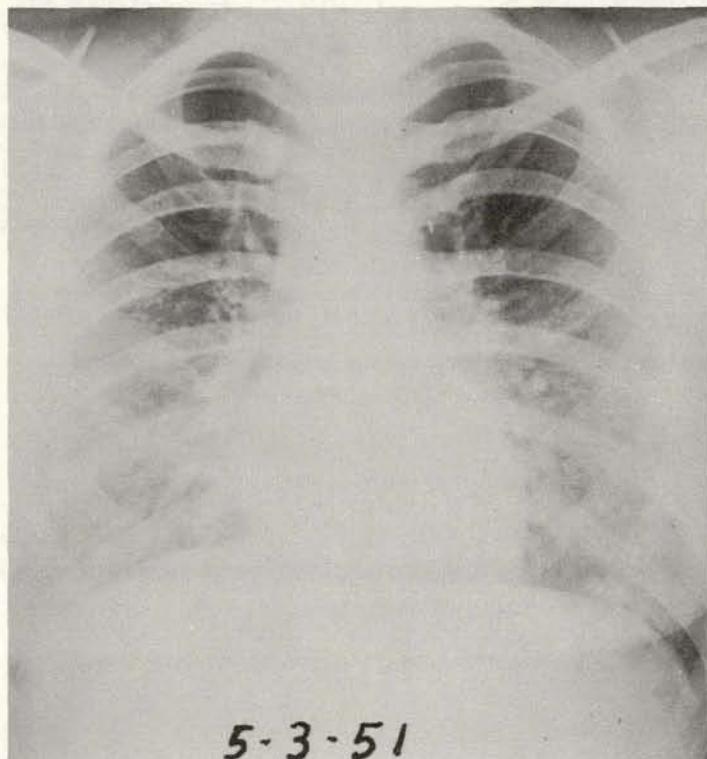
Same patient as shown in Figures 71 and 72. Roentgenograph of chest, May 3, 1951, 6 months after total thyroidectomy. I^{131} uptake was 16% in 24 hrs., chiefly in neck. I^{131} treatment, 50 mc. Desiccated thyroid, 2 grains daily begun.
